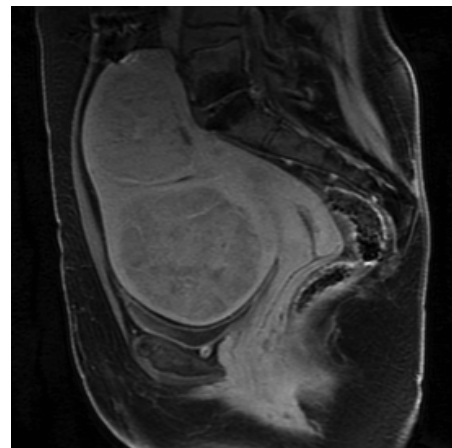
MRI picture in case of complicated, impacted fibroid.
